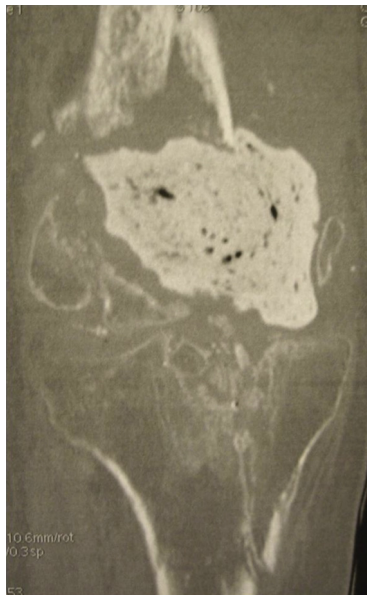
CT scan: complex fracture of femur and tibia, major bone defect, cement spacer.
